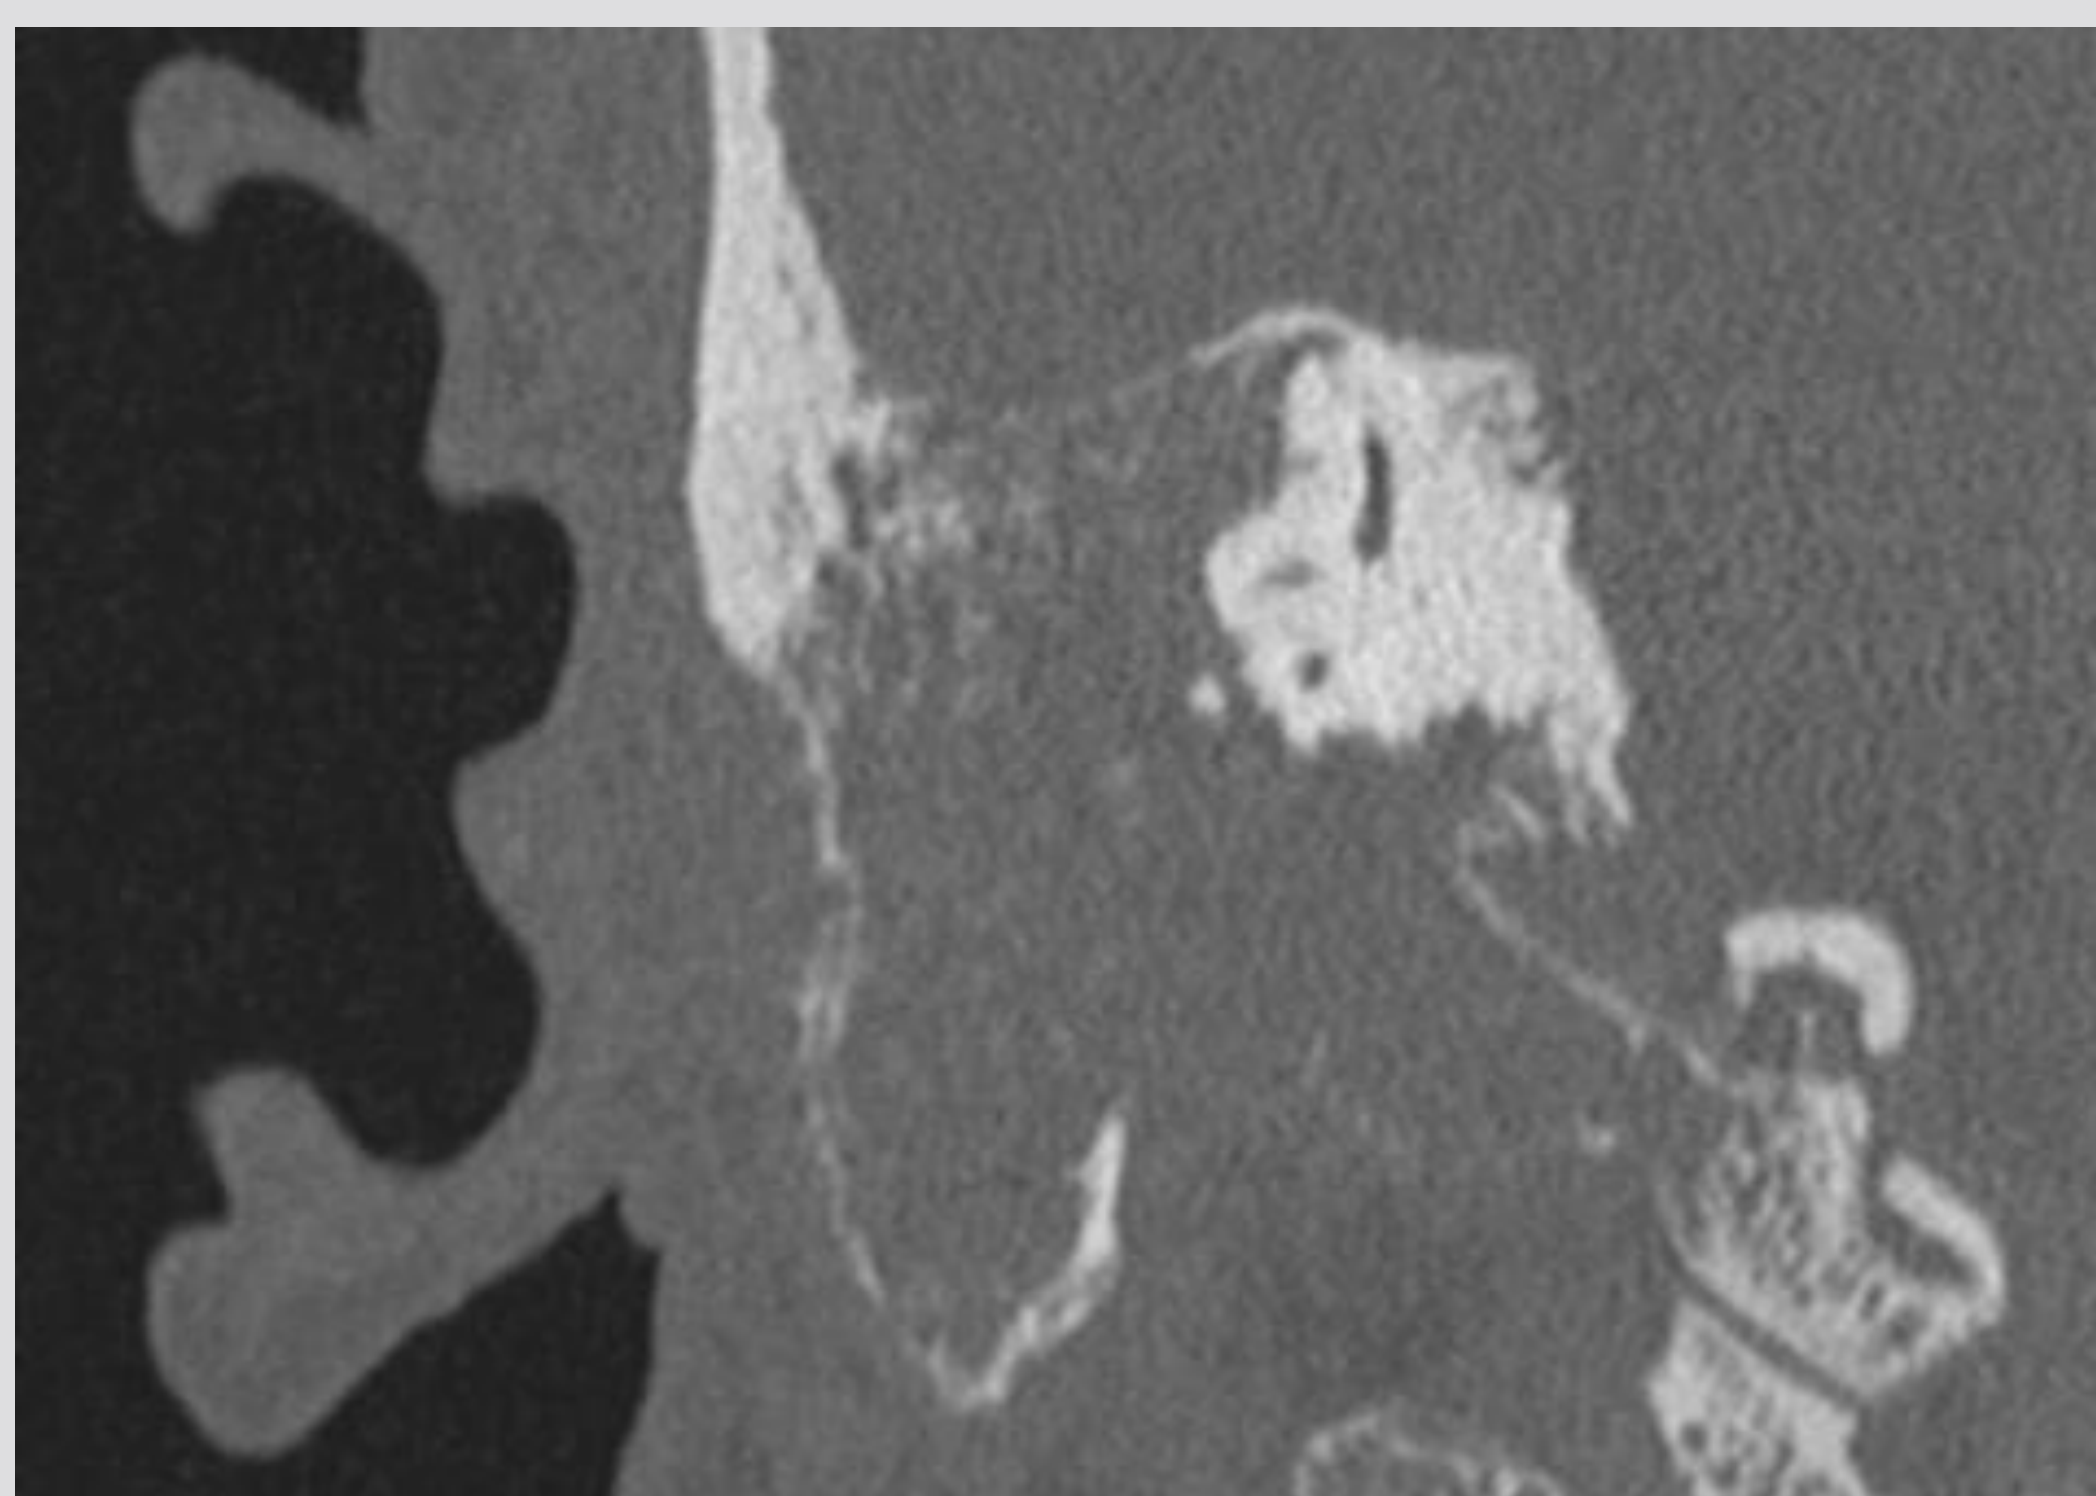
Representative coronal CT scan image from initial presentation.
